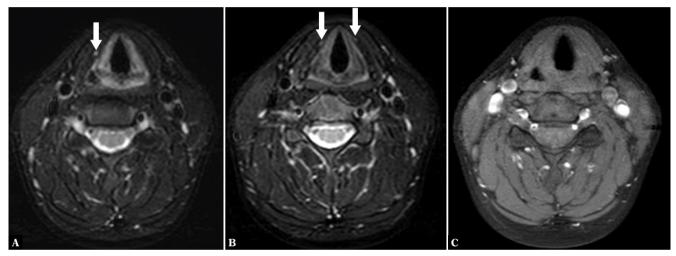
Axial MRI images of the neck demonstrating two lesions in the right lamina of the thyroid cartilage and one lesion on the left side, presenting high signal on T2-weighted images with fat suppression (arrows) (A, B), and no contrast enhancement on T1-weighted postcontrast image with fat suppression (C)
